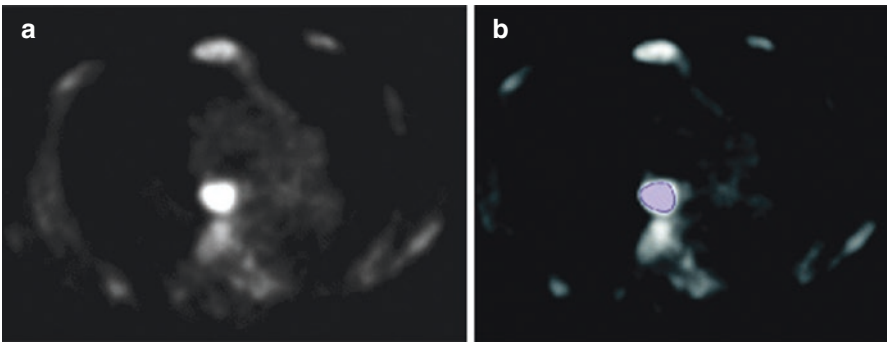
(a, b) Axial PET scan of the thorax shows FDG avid uptake by mediastinal lymph nodes in a case of lymphoma (*green*)
